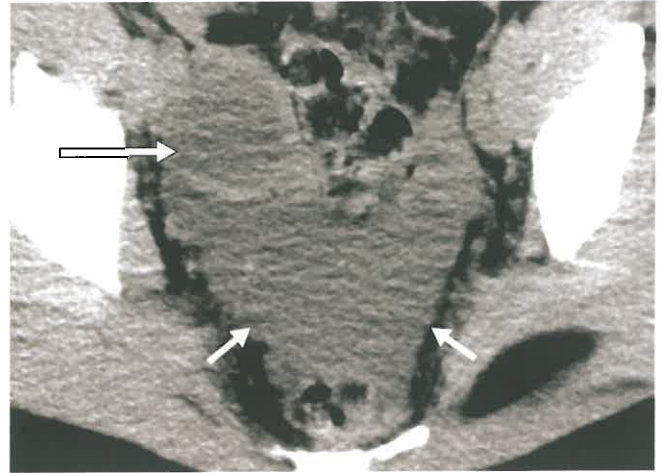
Peritoneal Inclusion Cyst. CT reveals a loculated fluid collection partially enveloping the right ovary (*large arrow*) and extending into the recesses of the peritoneal cavity (*small arrows*) in a patient with chronic pelvic pain. Attempts at needle and catheter drainage were unsuccessful. The patient became asymptomatic following oophorectomy.
